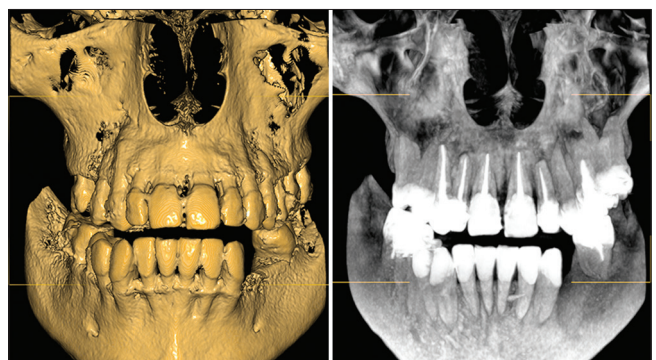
5-year follow-up CBCT
